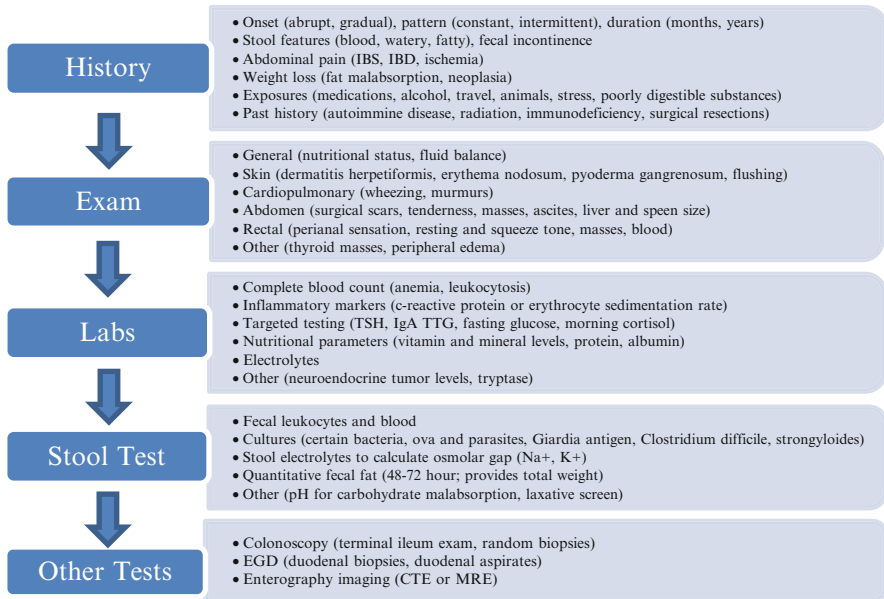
Algorithmic approach in the evaluation of the patient with chronic diarrhea. Adapted from Schiller LR. Chronic diarrhea. *Gastroenterology*. 2004;127:287–93. *IBS* irritable bowel syndrome, *IBD* inflammatory bowel disease, *TSH* thyroid-stimulating hormone, *TTG* tissue transglutaminase, *Na⁺* sodium, *K⁺* potassium, *CTE* computed tomography enterography, *MRE* magnetic resonance enterography
